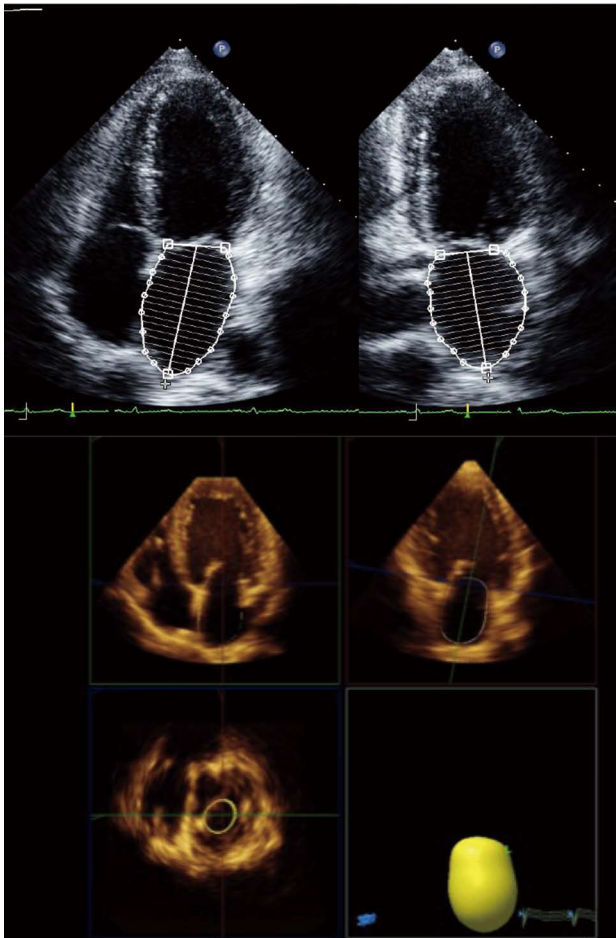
Left atrial volume quantification using two-dimensional (biplane Simpson's method - upper panel) and three-dimensional echocardiography (lower panel).
